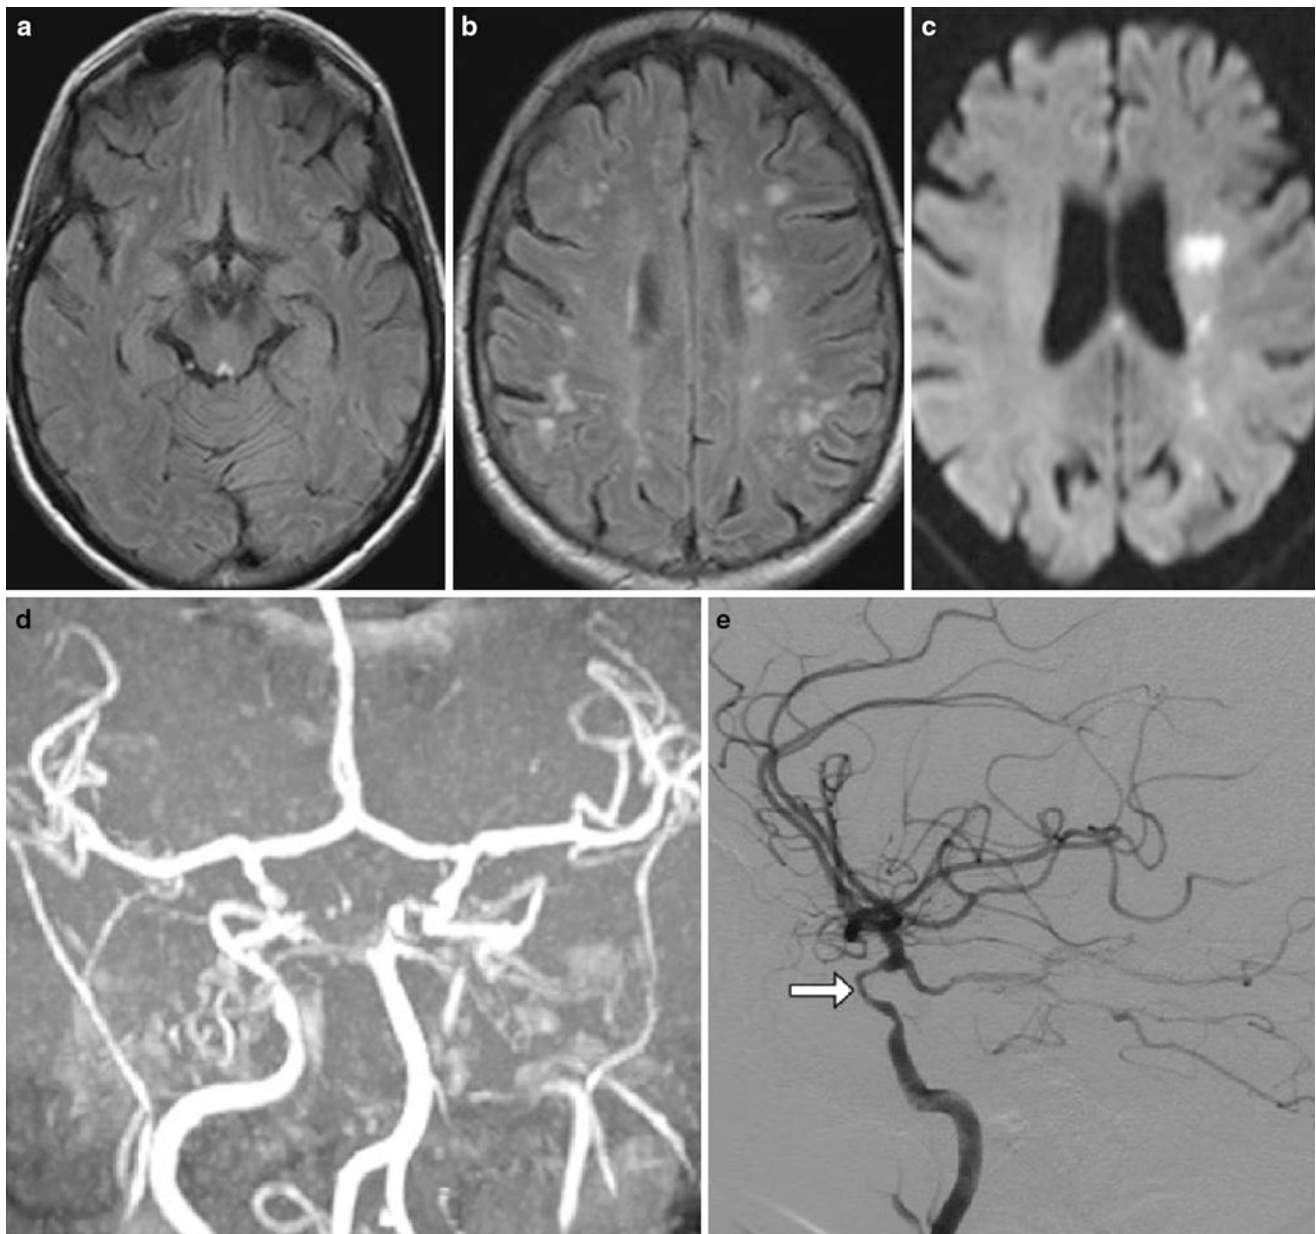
Giant cell (temporal) arteritis. A 61-year-old woman presenting with hemiparesis of the right side and psychosis. The psychotic symptoms disappeared subsequent to the administration of high-dose steroids. a, b Axial FLAIR images. c Axial DWI. d, e Giant cell (temporal) arteritis. A 61-year-old woman presenting with hemiparesis of the right side and psychosis. The psychotic symptoms disappeared subsequent to the administration of high-dose steroids.
